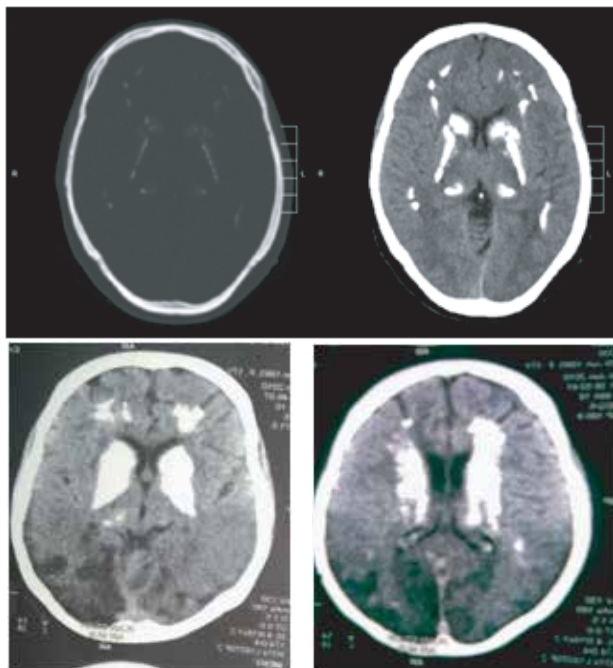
CT axial images
